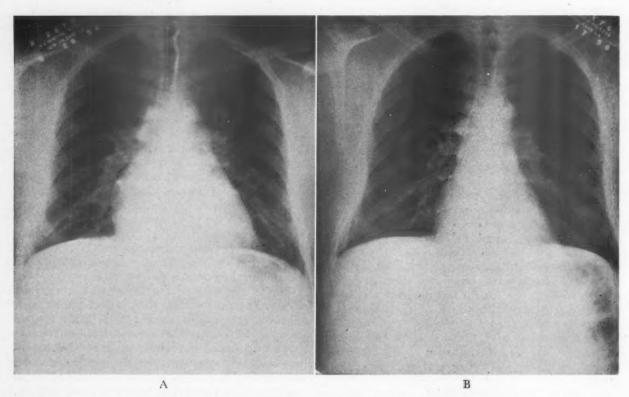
Case 5. A, x-ray film of chest taken on admission to hospital on May 28, 1958; B, x-ray film of chest taken on June 17, 1958. Cardiac enlargement noted initially is no longer present.
